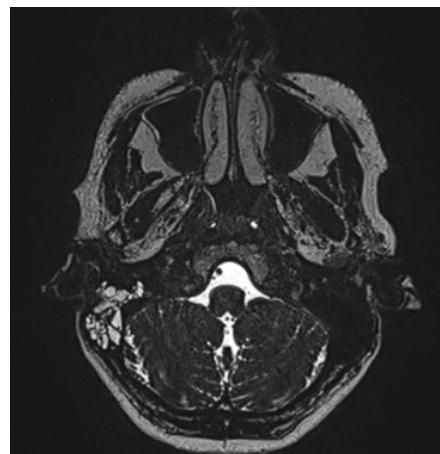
(MRI scan: persistence of liquidy content in the mastoid cells)
